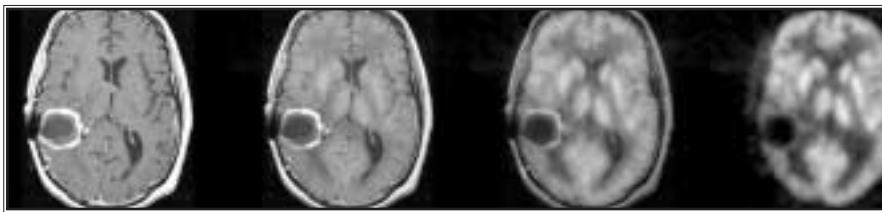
50-year-old man with right temporal anaplastic astrocytoma who underwent resection of the tumor, iodine-131 monoclonal antibody instillation into the cavity, chemotherapy, and external-beam radiotherapy. Contrast-enhanced MR image reveals abnormal enhancement around the lesion, and PET scan demonstrates this enhancement to be FDG-avid. MR and PET scans have been stable for more than one year, suggesting that this abnormality represents post-treatment necrosis.
